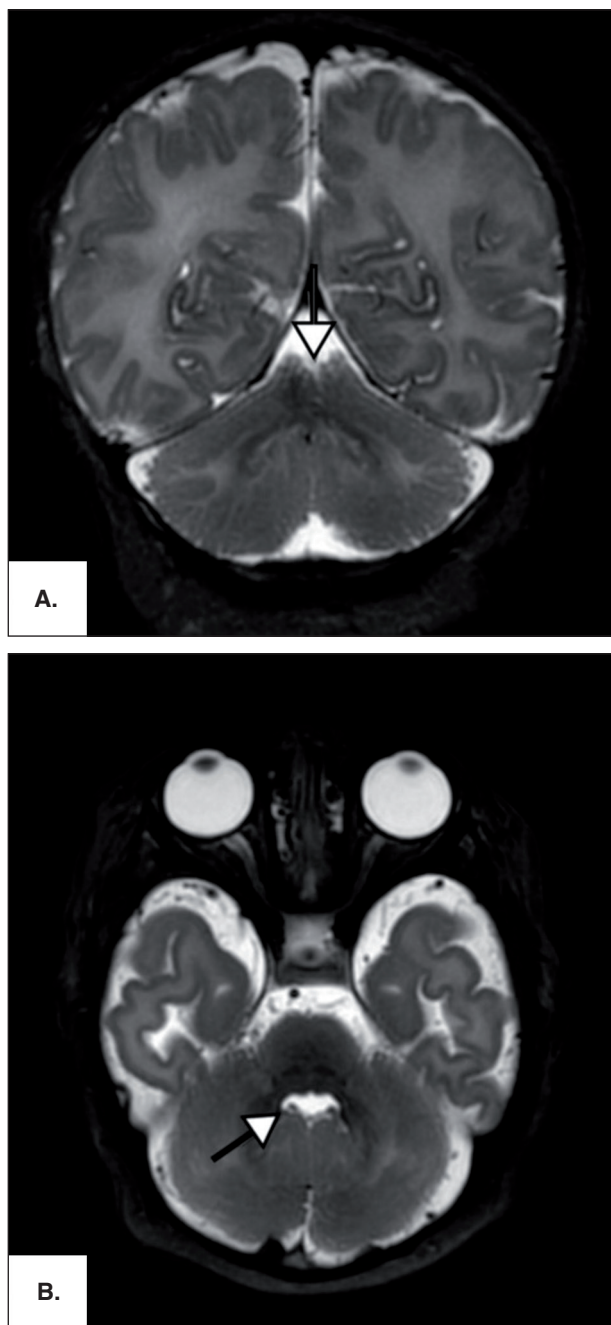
Brain magnetic resonance image (T2 weighted-imaging, coronal and axial planes) showing the vermian fissure (A, arrow) and the morphology of the fourth ventricle in the axial plane (B, arrow), which exhibits a characteristic “bat-wing” shape.
